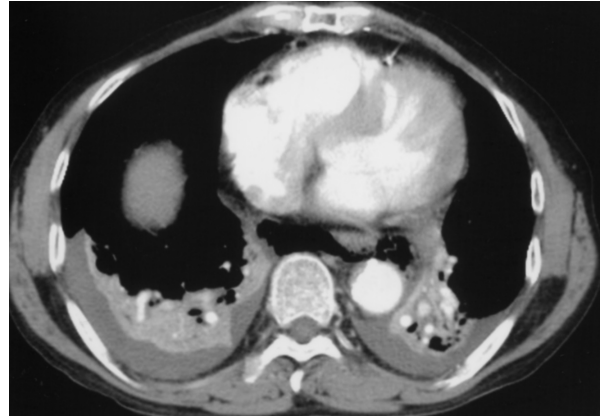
The computed tomography scan of the chest revealed bilateral pleural effusion, pneumomediastinum and a perforated distal esophagus, which extended into the left pleural cavity.
